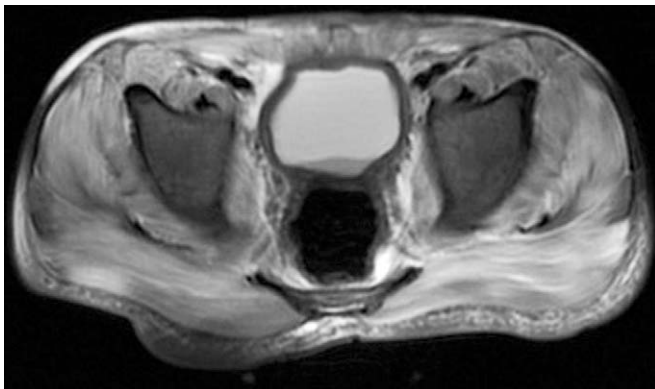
Axial T2-weighted image with fat saturation shows diffuse oedema of pelvic girdle muscles. There is extensive fascial oedema and dermal thickening with subcutaneous oedema.
